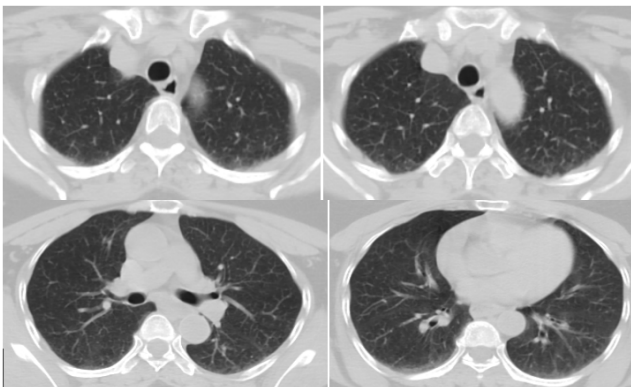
A 15 years female without any history of contact with tuberculosis presents with hemoptysis. HRCT was interpreted as normal.
